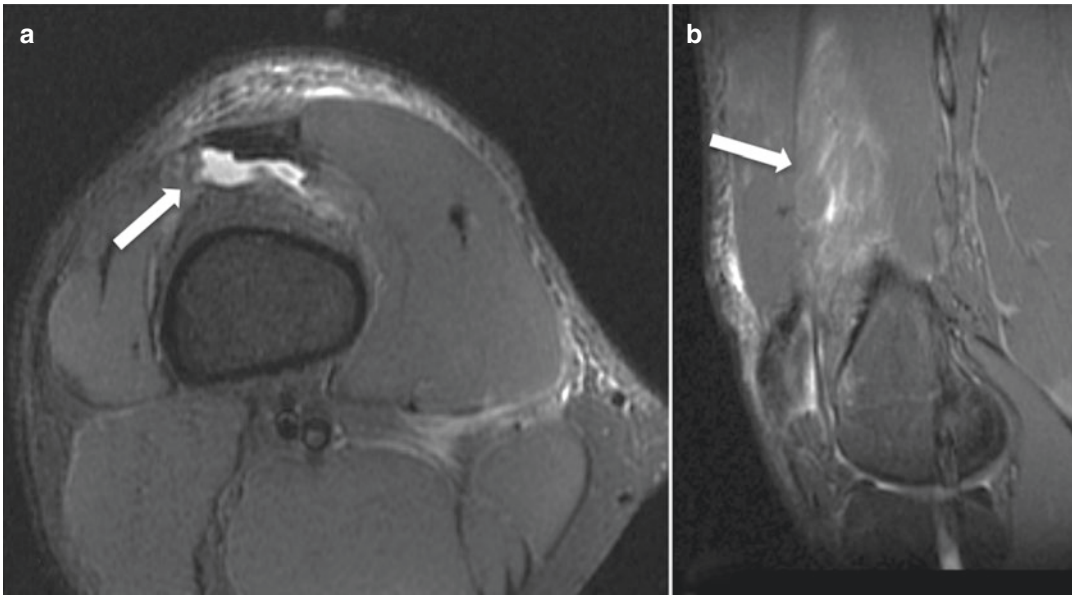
Quadriceps contusion. (a) Axial inversion-recovery MRI of the thigh demonstrating a hematoma posterior to the rectus femoris (arrow). (b) Sagittal
